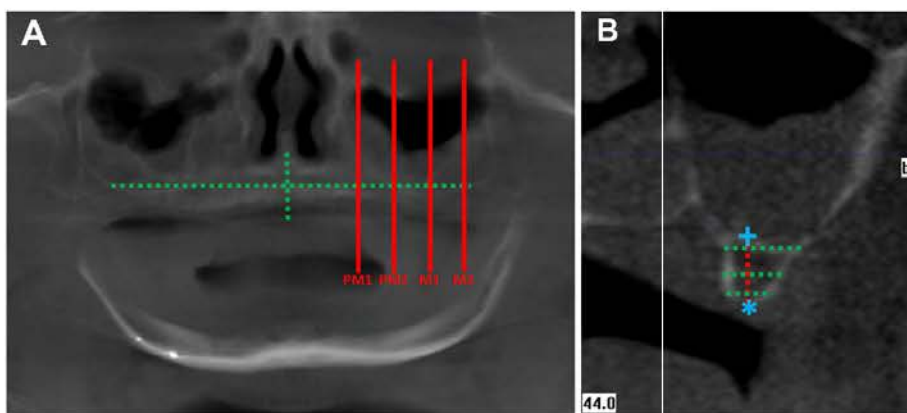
Alveolar ridge dimension measurement. A) On a panoramic slice of a preoperative CBCT scan ($t=0$) of an edentulous patients, a section of interest (SOI) was selected at both sites at 21, 28, 36 and 43 mm, and 22, 29, 37 and 44 mm from the incisive foramen, respectively in females and males. SOIs allocated the area of the first premolar (PM1), second premolar (PM2), first molar (M1) and second molar (M2). B) Example of bone height (BH) measurement between the most coronal point of the alveolar crest (*) and the most coronal point of the sinus floor (+). Bone width (BW) was evaluated at a height of 1, 3, and 7 mm apically of (*).
